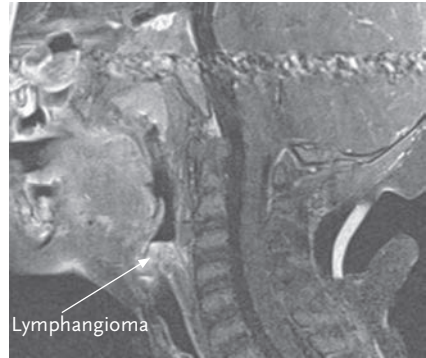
MRI scan of a lymphangioma of the larynx.
